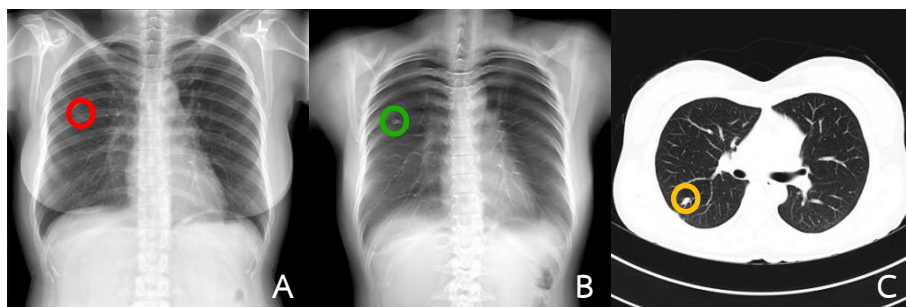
The images of lung nodule in difference modality (A) digital radiography (B) digital tomosynthesis and (C) computed tomography.
